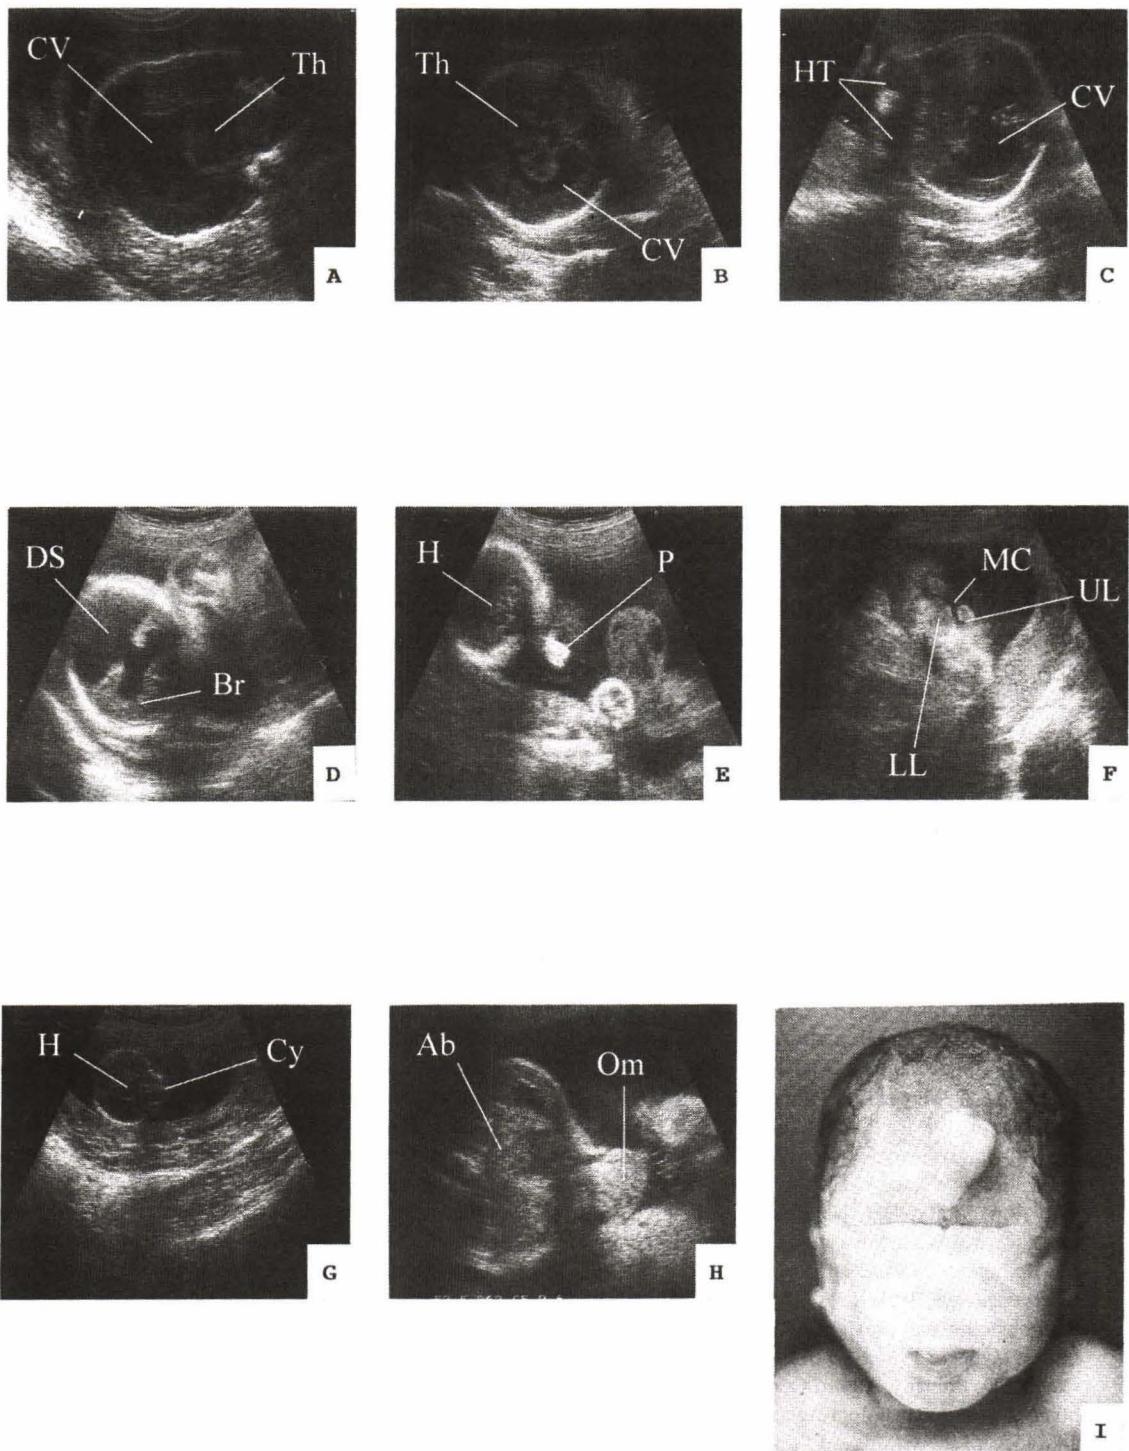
Sonographic images show common ventricle; CV (A-C), dorsal sac; DS (D), fused thalamus; Th (A) in alobar type, non-fused thalamus; Th (B) in semilobar type, hypotelorism; HT (C), proboscis; P (E), midline cleft; MC (F), cyclopia; Cy (G), and small omphalocele; Om (H). Neonatal appearance of proboscis is shown in figure 1. (Br=brain, H=head, Ab=abdomen).
